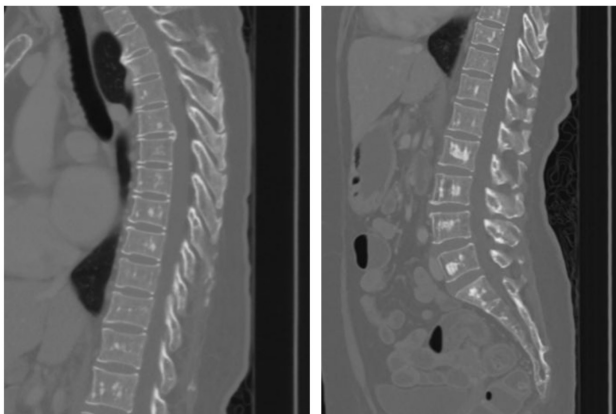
Computed Tomography (CT) of the spine. Sagittal and coronal reconstructions demonstrate multiple discrete, hyperdense sclerotic lesions (bone islands) distributed within the vertebral bodies and posterior elements, without evidence of cortical destruction or soft tissue mass, supporting a benign etiology.
